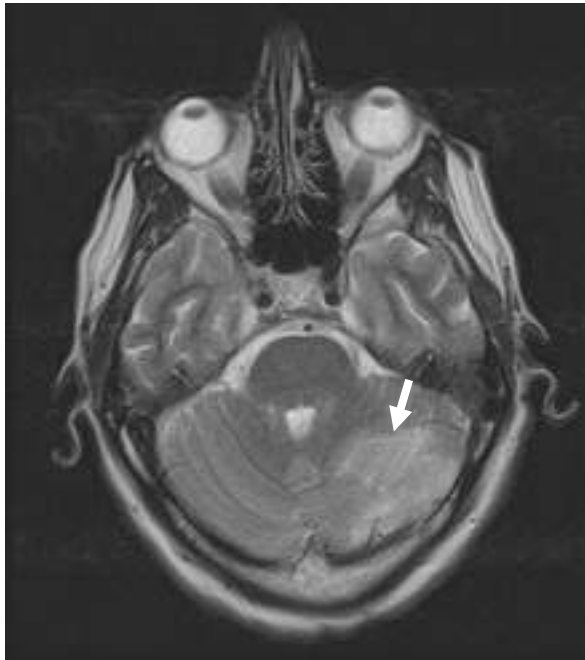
weighted axial magnetic resonance imaging of the brain disclosed cerebellar infarctions in the left superior cerebellar artery region (arrow).
